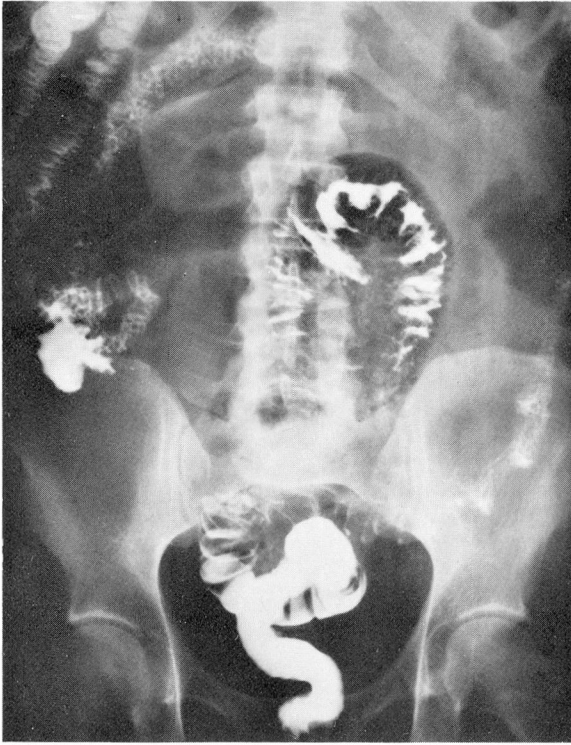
Roentgenogram made on July 24, 1961, showing evidence of dilated loop of small intestine, with some retention of barium in the stomach from barium swallowed two days previously.
